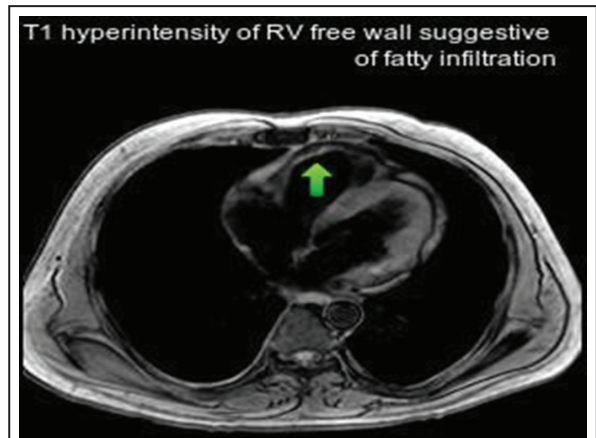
MRI showing T1 hyperintensity of RV free wall.
